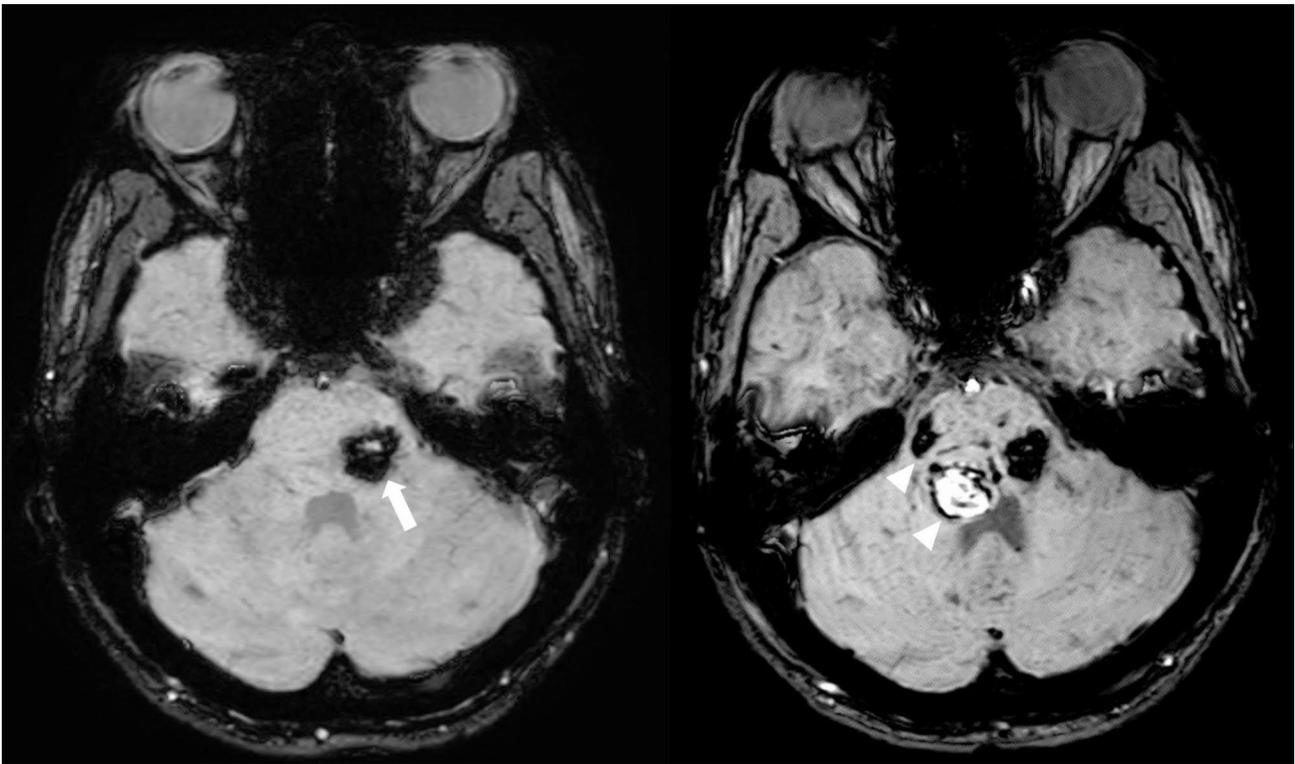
Left – Initial MRI: Axial Susceptibility Weighted Image (SWI) at the level of the brainstem demonstrates a prominent area of susceptibility related signal loss within the left aspect of the pons compatible with hemorrhage (white arrow). Right – Follow-up MRI 2 weeks later: Axial SWI at the same level demonstrates new prominent areas of hemorrhage within the right aspect of the pons (white arrowheads)
